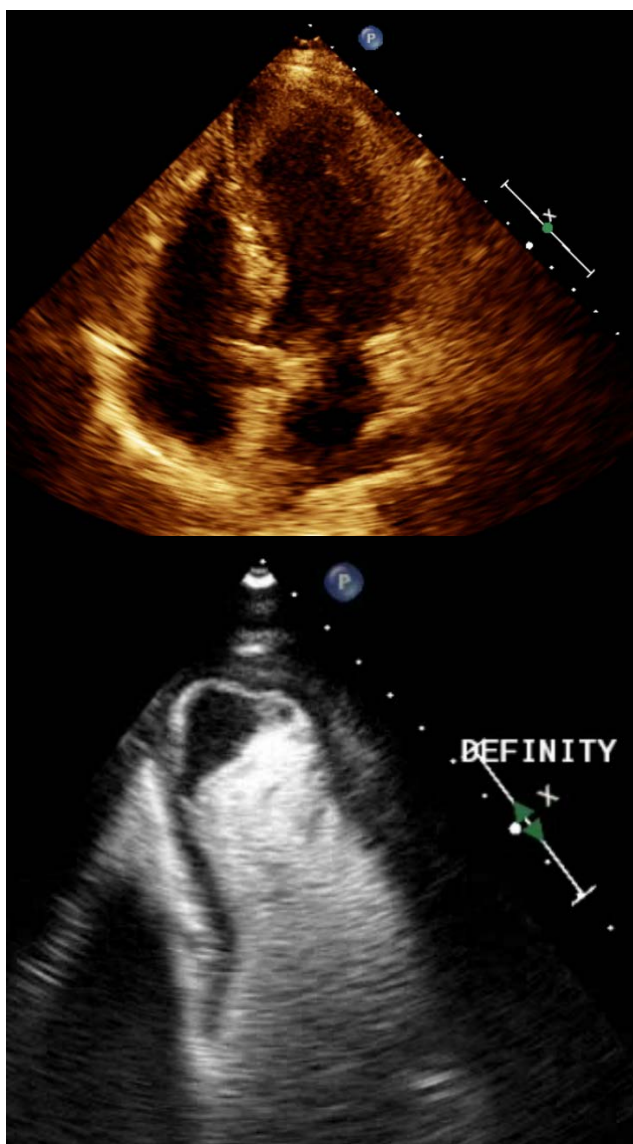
Echocardiograms in the apical 4-chamber view without (left) and with (right) contrast administration, showing a large apical LV thrombus in the dyskinetic region of the apex and apical septal wall segments.
